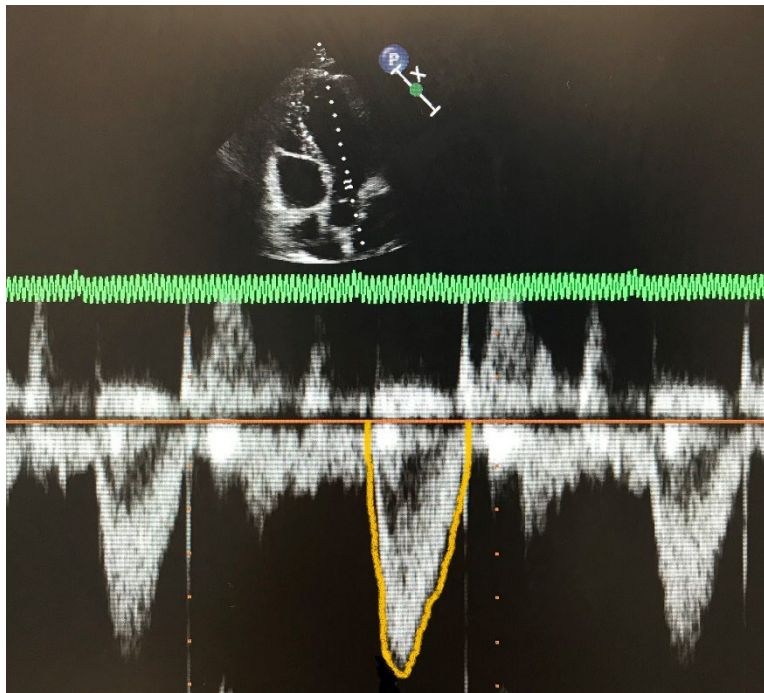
Five chamber view, pulsed wave Doppler of left ventricular outflow tract velocity time integral
